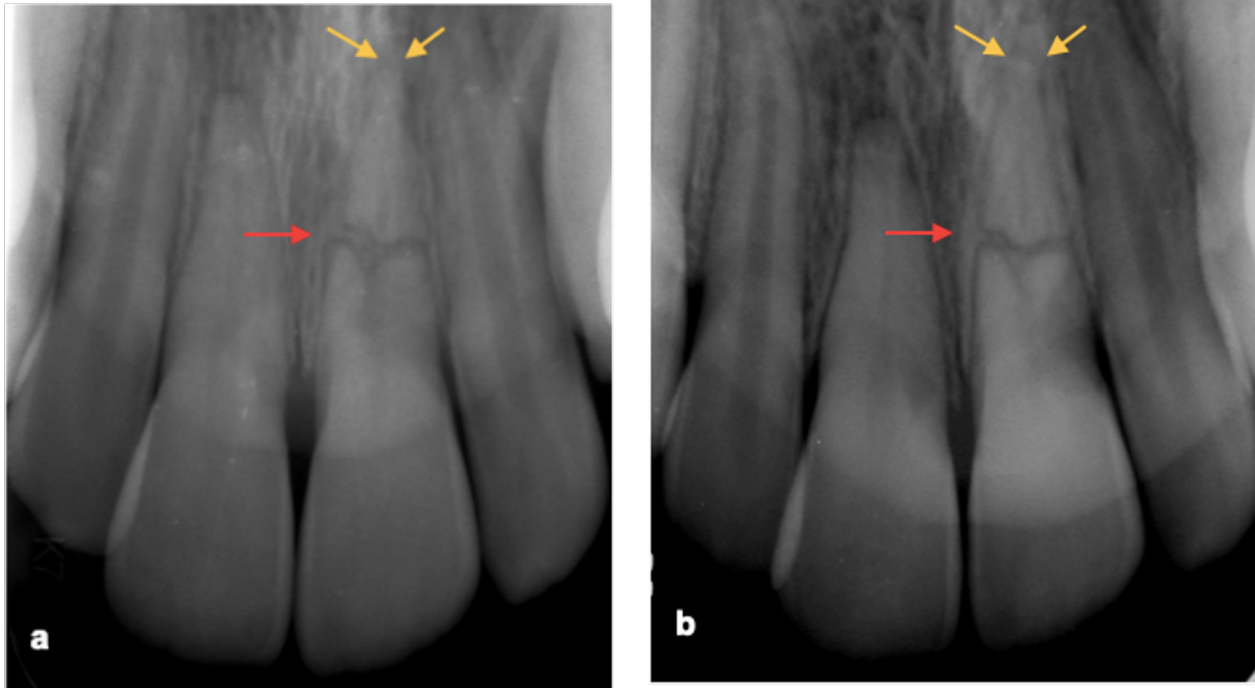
Radiographic follow-up at a) 2 years and b) 3 years (Yellow arrows indicate the apex closure and red arrows indicate the healing of the fracture line with calcified tissue and connective tissue.)
